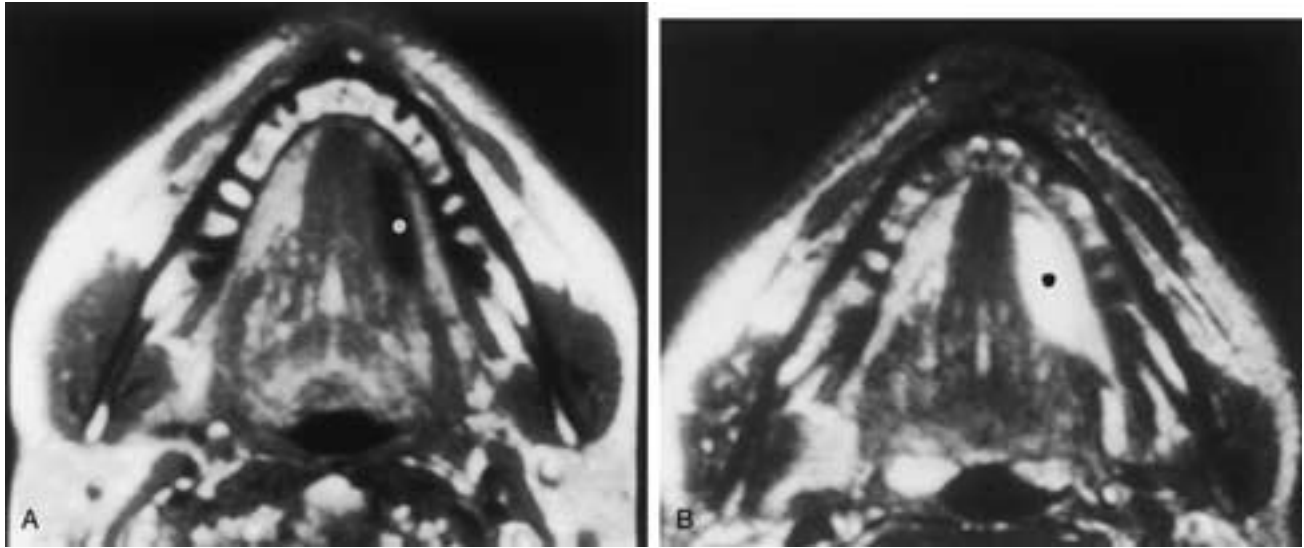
Simple ranula. (A) T1-weighted and axial (B) T2-weighted MR images reveal a small lesion in the left sublingual space (*dots*) hypointense on A and hyperintense on B, compatible with the presence of fluid.
